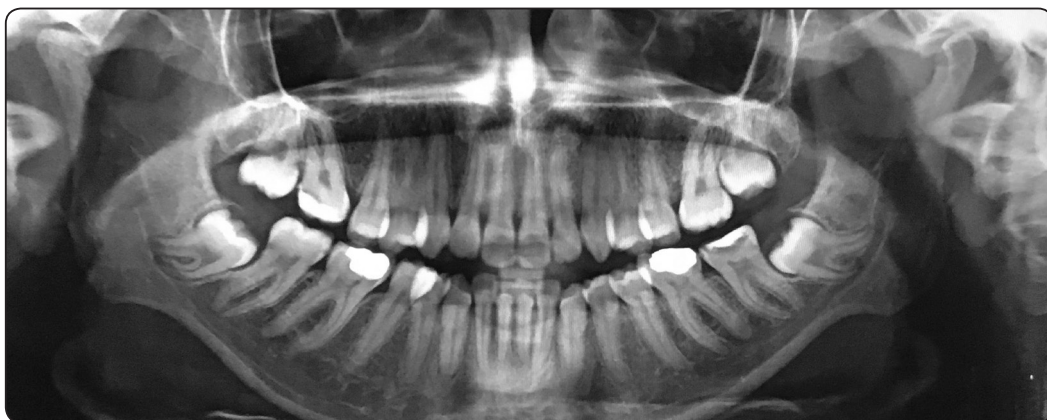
Panoramic x-ray showing bilaterally impacted mandibular 3<sup>rd</sup> molar teeth having the same Pederson difficulty index.
